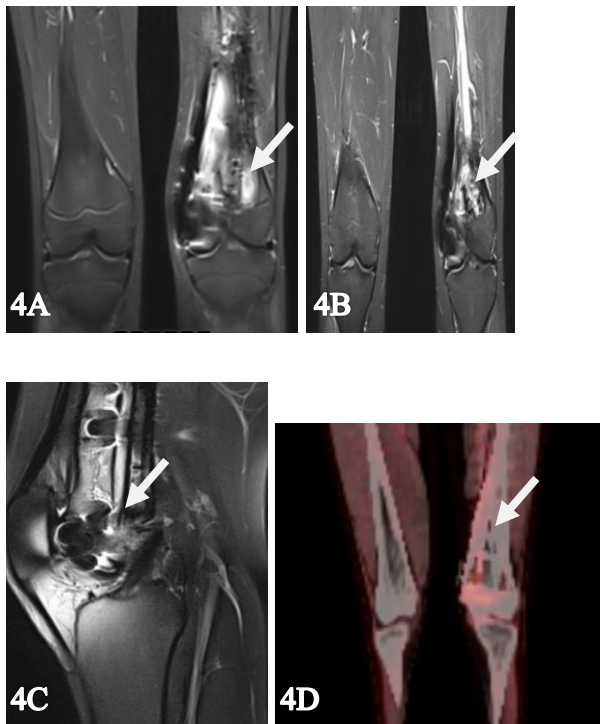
Sections from different postoperative imaging of the case. 4.A. Postop 7th month MRI coronal (proton T2 sequence). 4.B. Postop 5th year MRI coronal (proton T2 sequence). 4.C. Postop 5th year MRI sagittal (proton T2 sequence). 4.D. Postop after 5th year PET coronal (proton T2 sequence). ECI-applied target-bone indicated by the arrow.
